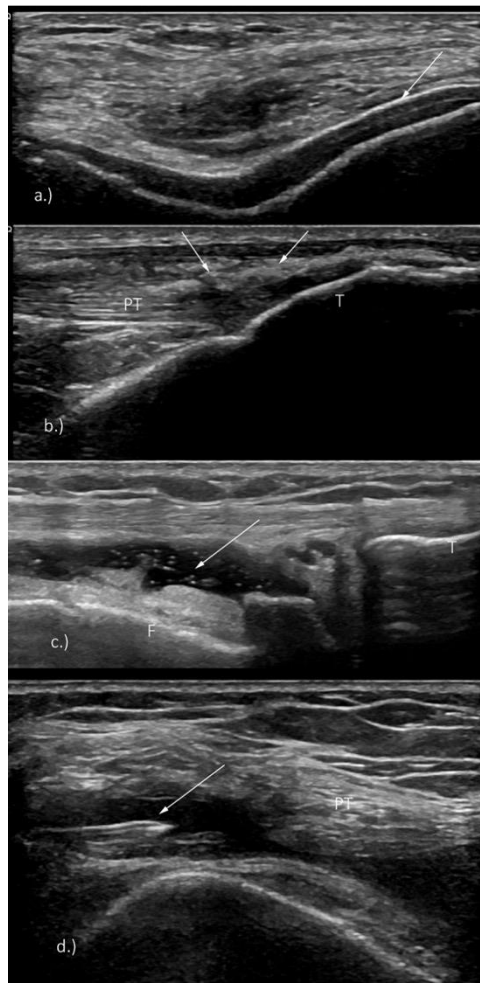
Double contour sign at the level of the hyaline femoral cartilage; b) Arrows -Hyperechoic cloudy aggregates were detected at the level of the patellar tendon (PT) bilaterally, T – tibia cortical bone; c) Lateral parapatellar recess distended by a hypoechoic mass (arrow) containing hyperechoic dots, F – femoral bony cortex, T – tibia bony cortex; d) Transverse scanning of the suprapatellar bursa and ultrasound guided aspiration of the knee effusion (arrow – tip of the needle, PT – patellar tendon). The salivary glands US evaluation showed a normal volume and echotexture of the parotid, submandibular and sublingual glands. In the proximity of the superior pole of both parotid glands, unencapsulated subcutaneous fat tissue masses were detected (Figure 3).
